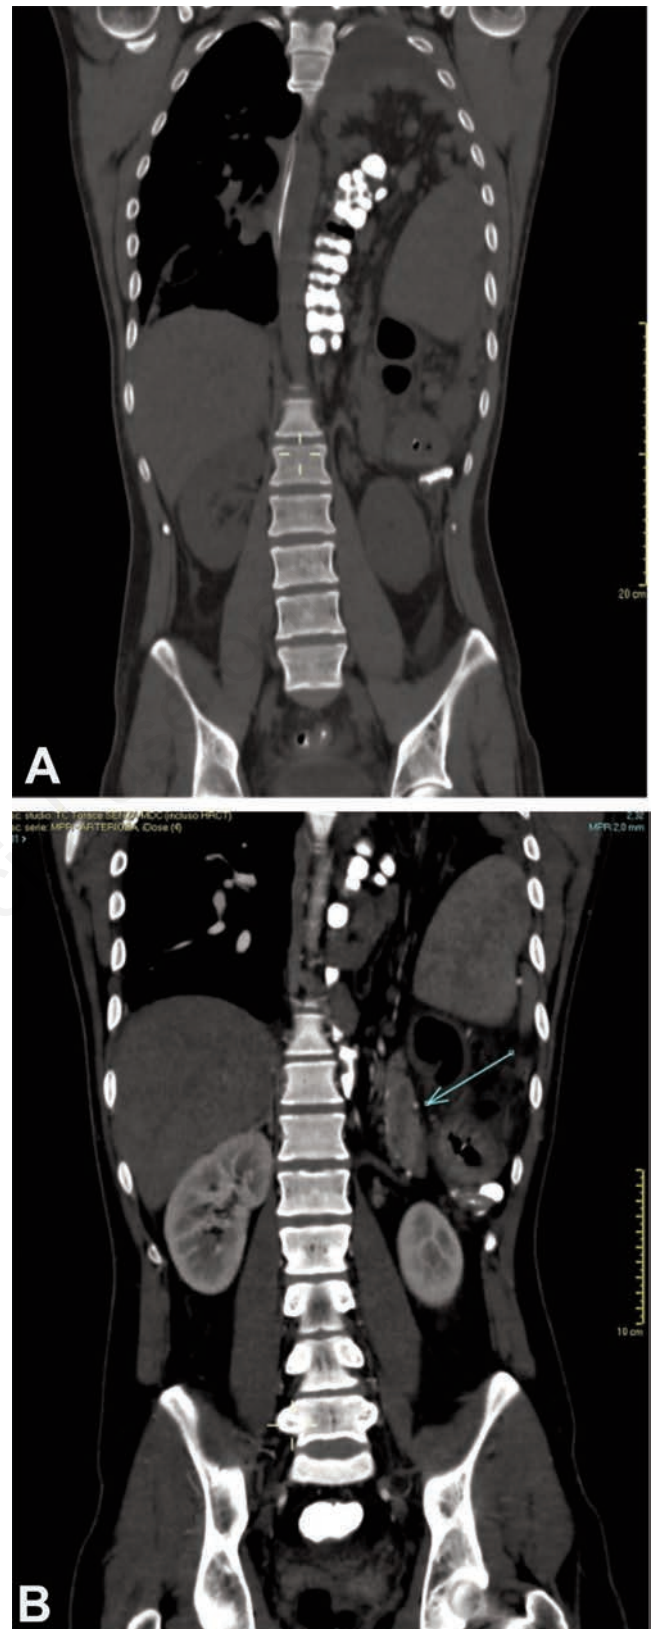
Contrast-enhanced computed tomography, coronal plane. (A) Hiatal hernia; (B) herniation of the stomach, the body and tail of the pancreas (arrow), and the first part of the duodenum.
